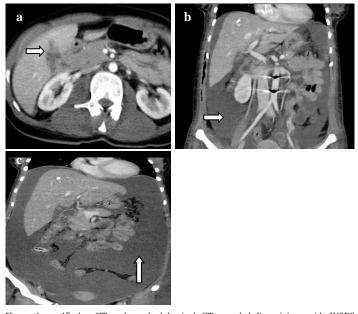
a: 1<sup>st</sup> day CT, enhanced abdominal CT revealed liver injury with WSES classification grade I. b:  $2^{nd}$  day CT, intraabdominal free fluid was gradually increasing. c:  $3^{rd}$  day CT, an abdominal distention developed, the gall bladder was never full.
